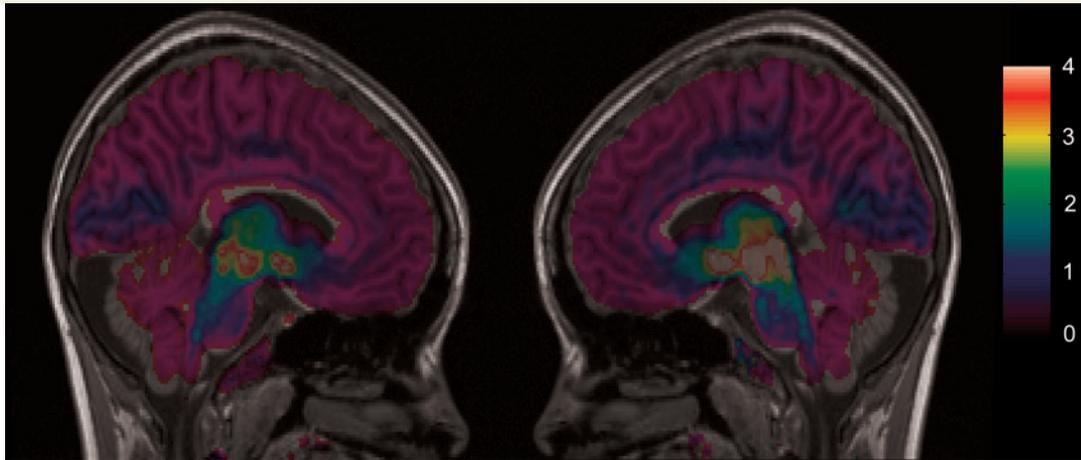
The ^{11}C -DASB PET image of a patient with seasonal affective disorder in summer and in winter. Cerebral serotonin transporter binding in a 22-year-old female S-carrier scanned symptom-free in the summer (left) and during winter when she had severe depressive symptoms and a SIGH-SAD score of 27 (right). The quantified ^{11}C -DASB PET image is overlaid on a T_1 -weighted structural magnetic resonance image. The patient had the highest cerebral serotonin transporter in the winter.
